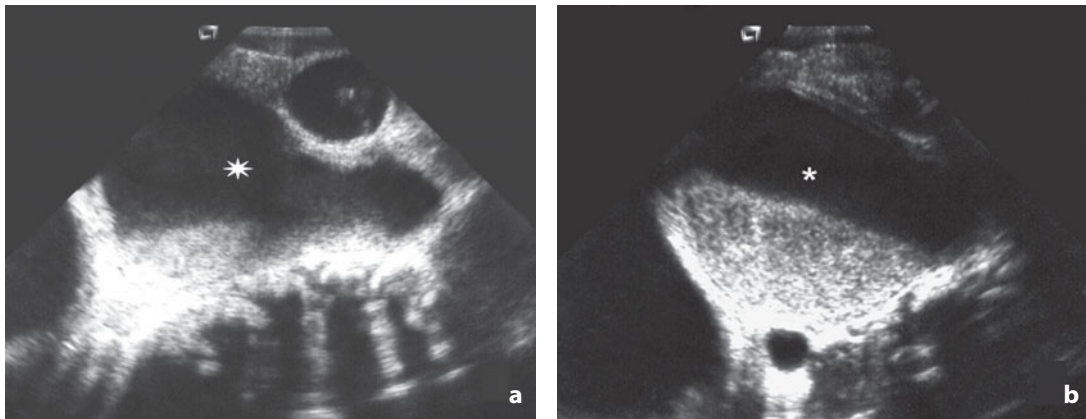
Vaginal atresia. Longitudinal (a) and transverse (b) sonograms show large pelvic mass (asterisk) with nonuniform structure due to collection of fluid with prevalent development in the superior portion and a tapered appearance in the more caudal portion near the constricted tract
